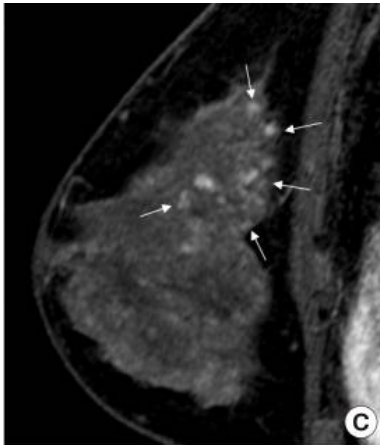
Early contrast-enhanced sagittal magnetic resonance image shows regional, non-mass enhancement (arrows) in the moderate background parenchymal enhancement.
